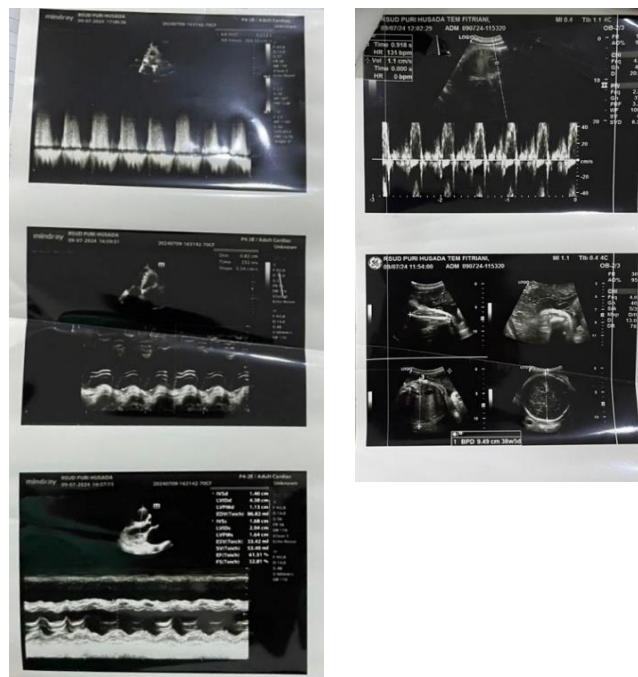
Transthoracic Echocardiography Of The Patient
